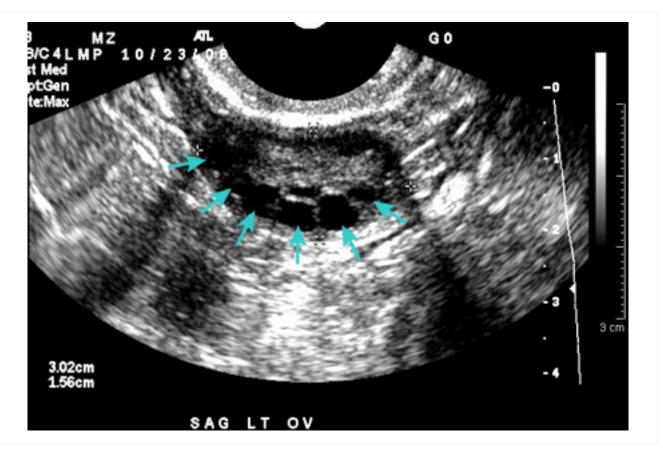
Polycystic ovarian ultrasound
